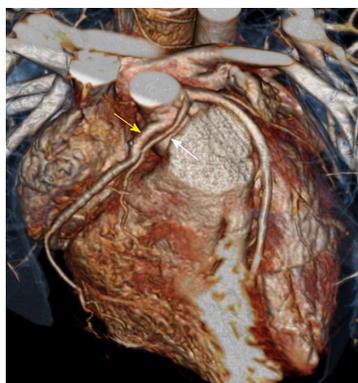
Coronary computed tomography after neo-ostium formation of right coronary artery with saphenous vein graft operation. Yellow arrow is the graft vessel and white arrow is the original right coronary artery.
